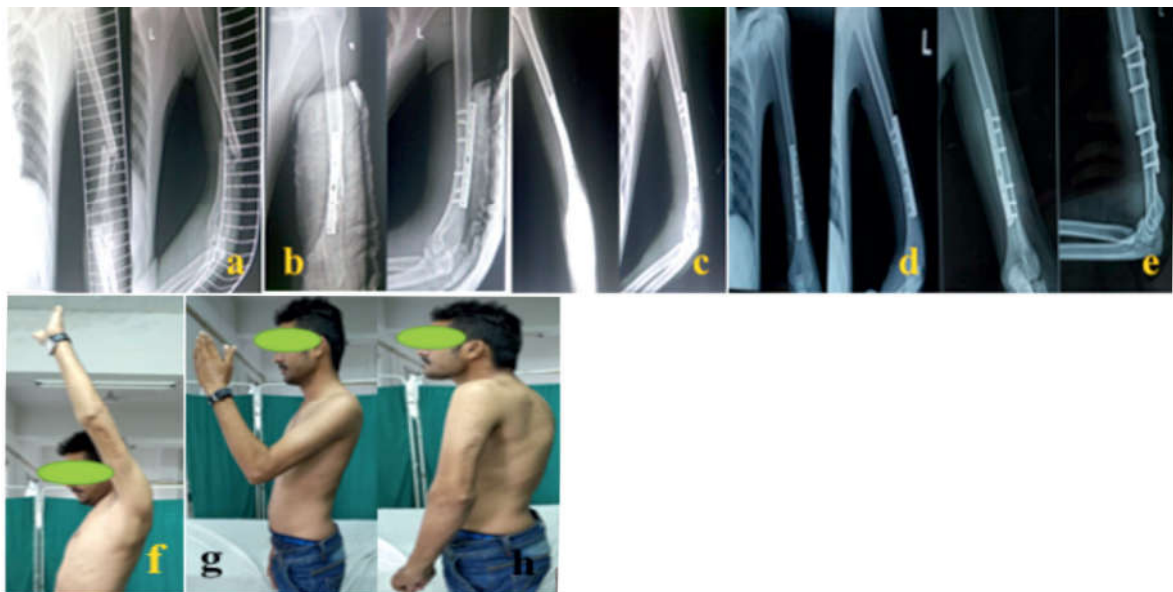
A 23-year-old male, trauma due to road traffic accident was treated with the ORIF technique. a Preoperative radiograph shows a humeral shaft fracture (OTA 12-B2). b post operative, c 1 month follow up, d 3 months follow up, e 12 months follow up radiographs. f, g & h clinical images performing function at shoulder and elbow joint.
